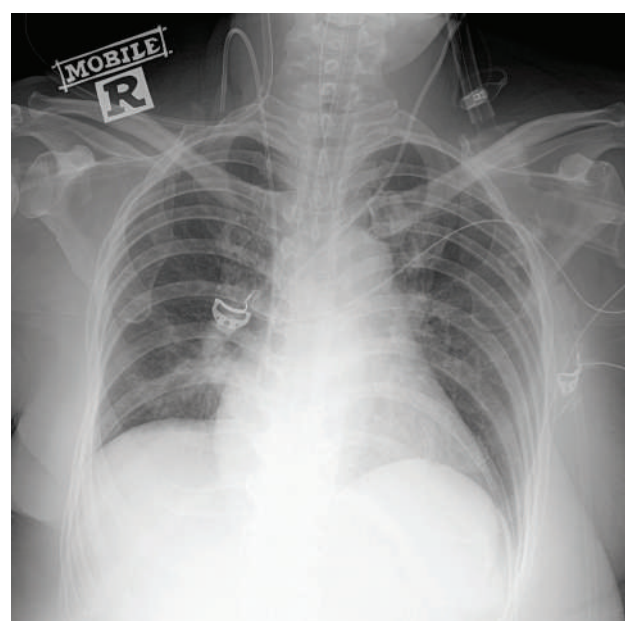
Chest radiograph showing resolution of cardiomegaly with marked improvement of pulmonary congestion by day nine of hospitalization.
